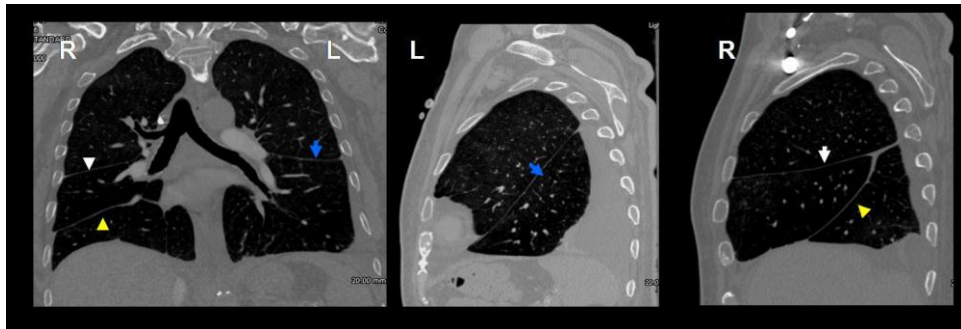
The coronal CT image on the left shows the right minor (horizontal) fissure (white arrow), right major fissure (yellow arrow), and left major (oblique) fissure. These structures are also seen on the right lateral sagittal CT image on the right. The minor fissure separates the right superior lobe from the right middle lobe. The right major fissure separates the right upper and middle lobes from the inferior lobe. The left major fissure (middle CT image) separates the left upper and lower lobes (*Joseph, 2010*).
